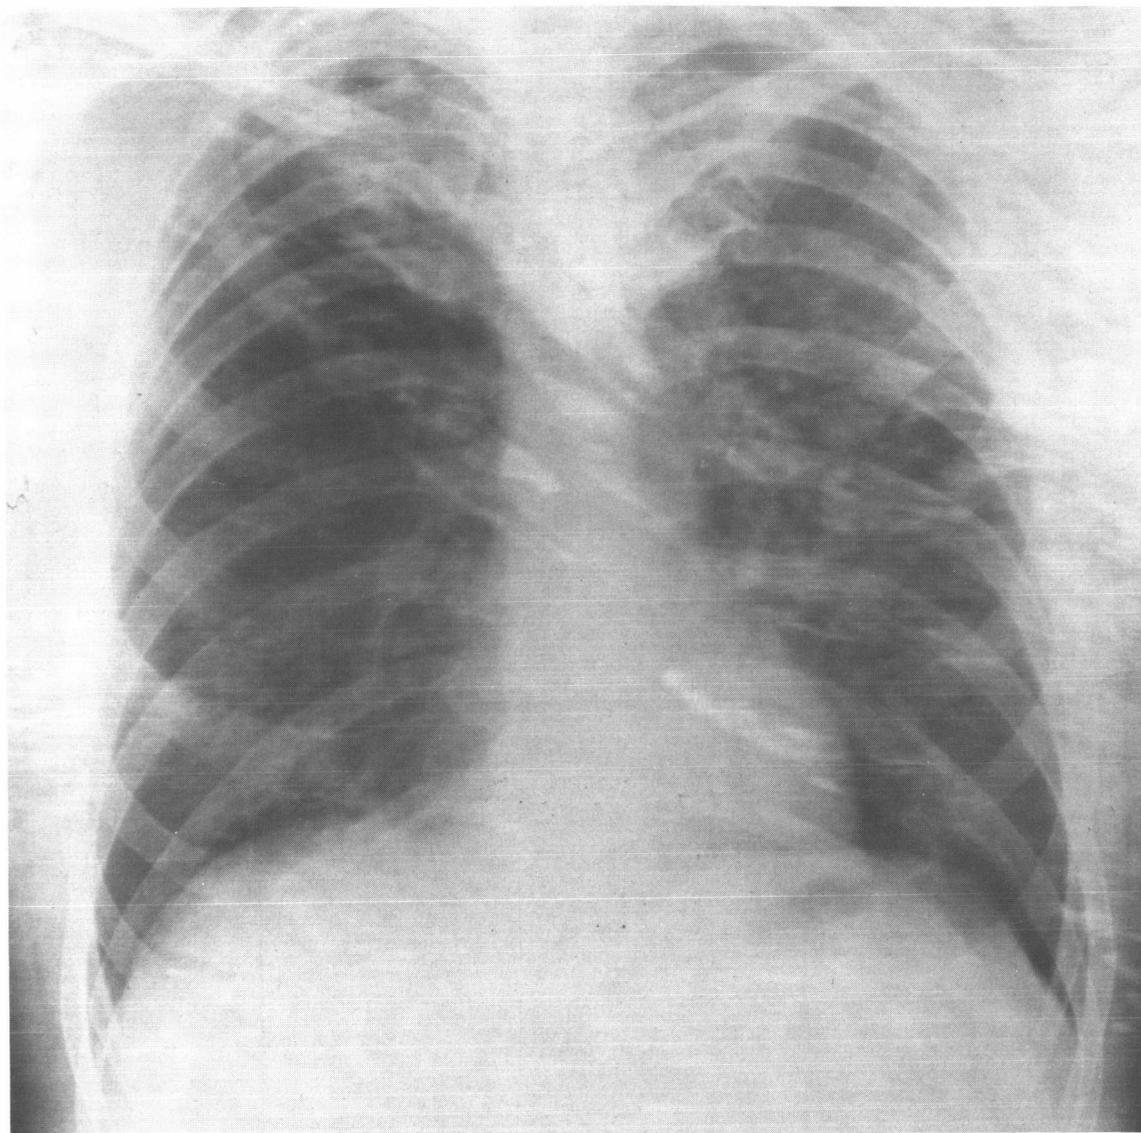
Chest Roentgenogram Suggestive of Alveolar Exudative Fillings
